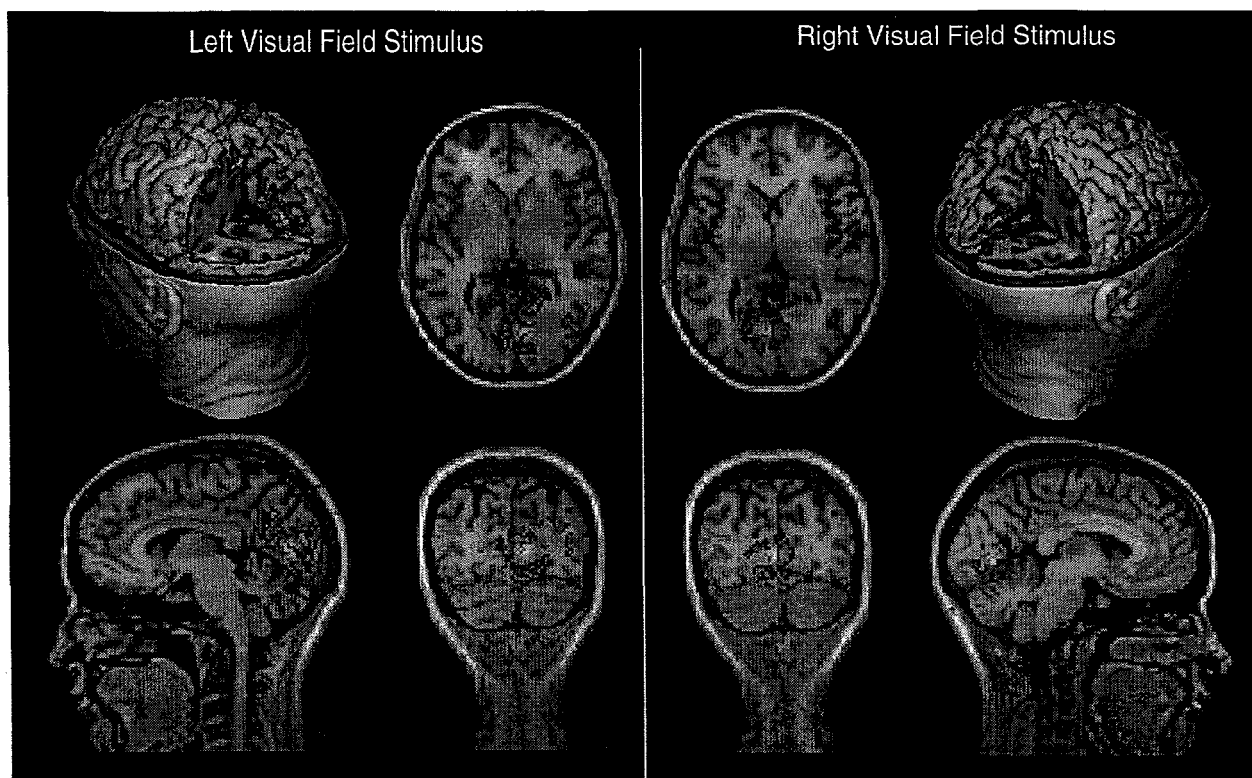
Four views of a region that was found to contain activity at a 95% probability level for both a left and a right visual field stimulus, at 110 ms latency. The two-dimensional views show the probable regions of activity within the anatomical MRI data. The horizontal and coronal views are from the top and from the back of the subject, respectively; the sagittal views are from the left for the left visual field stimulus panel and from the right for the right visual field stimulus panel. The three-dimensional views are useful for showing the location of the regions relative to other brain structures. These results indicate that the probability of activity is maximal in the calcarine region of the hemisphere contralateral to the visual field stimulated.
